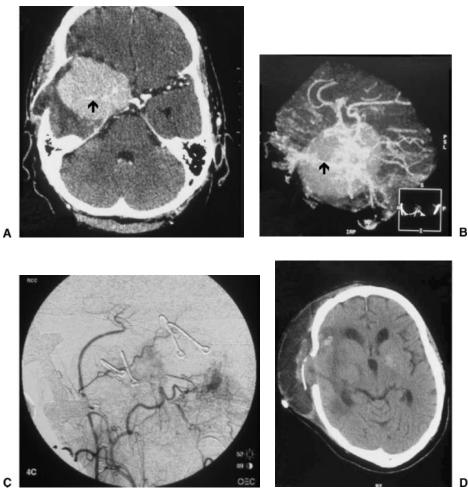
(A) A 45-year-old male with two previous resections of an atypical meningioma. The patient has received radiosurgery and chemotherapy. Previous resections were limited due to incorporation within the tumor of the superior division M2 (arrow). (B) Three-dimensional CT reconstruction of the blood vessels' relationship to the tumor. M2 division within the tumor shown (arrow). (C) Intraoperative angiogram shows radial artery EC-IC bypass to the distal portion of the involved M2 division. (D) Postoperative CT scan showing tumor resection within the sylvian fissure. CT, computed tomography; EC-IC, external carotid-internal carotid.
